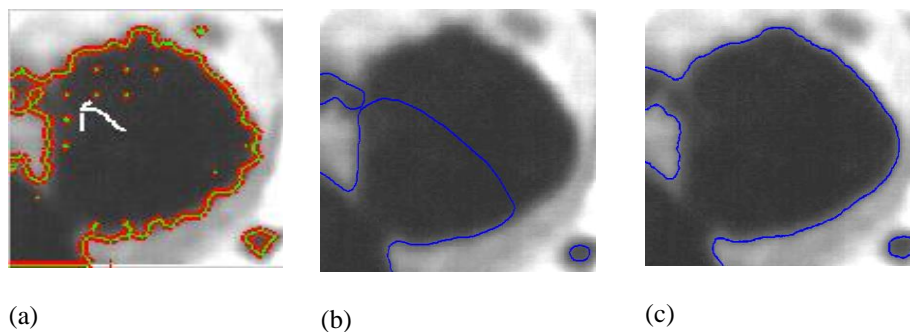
Experiment on another MRI image of a heart in different angle. The final results using the C-V, SGLACM, and proposed methods are shown in the first, second, and third columns for $\alpha=0.084$ and $\sigma = 1.0$, respectively.
